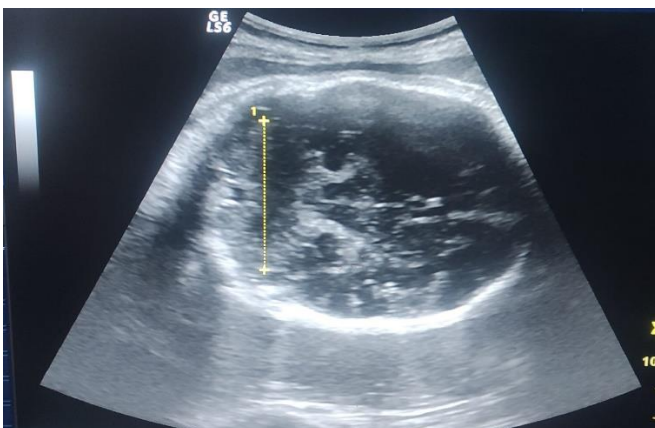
Sonographic measurement of transcerebellar diameter
